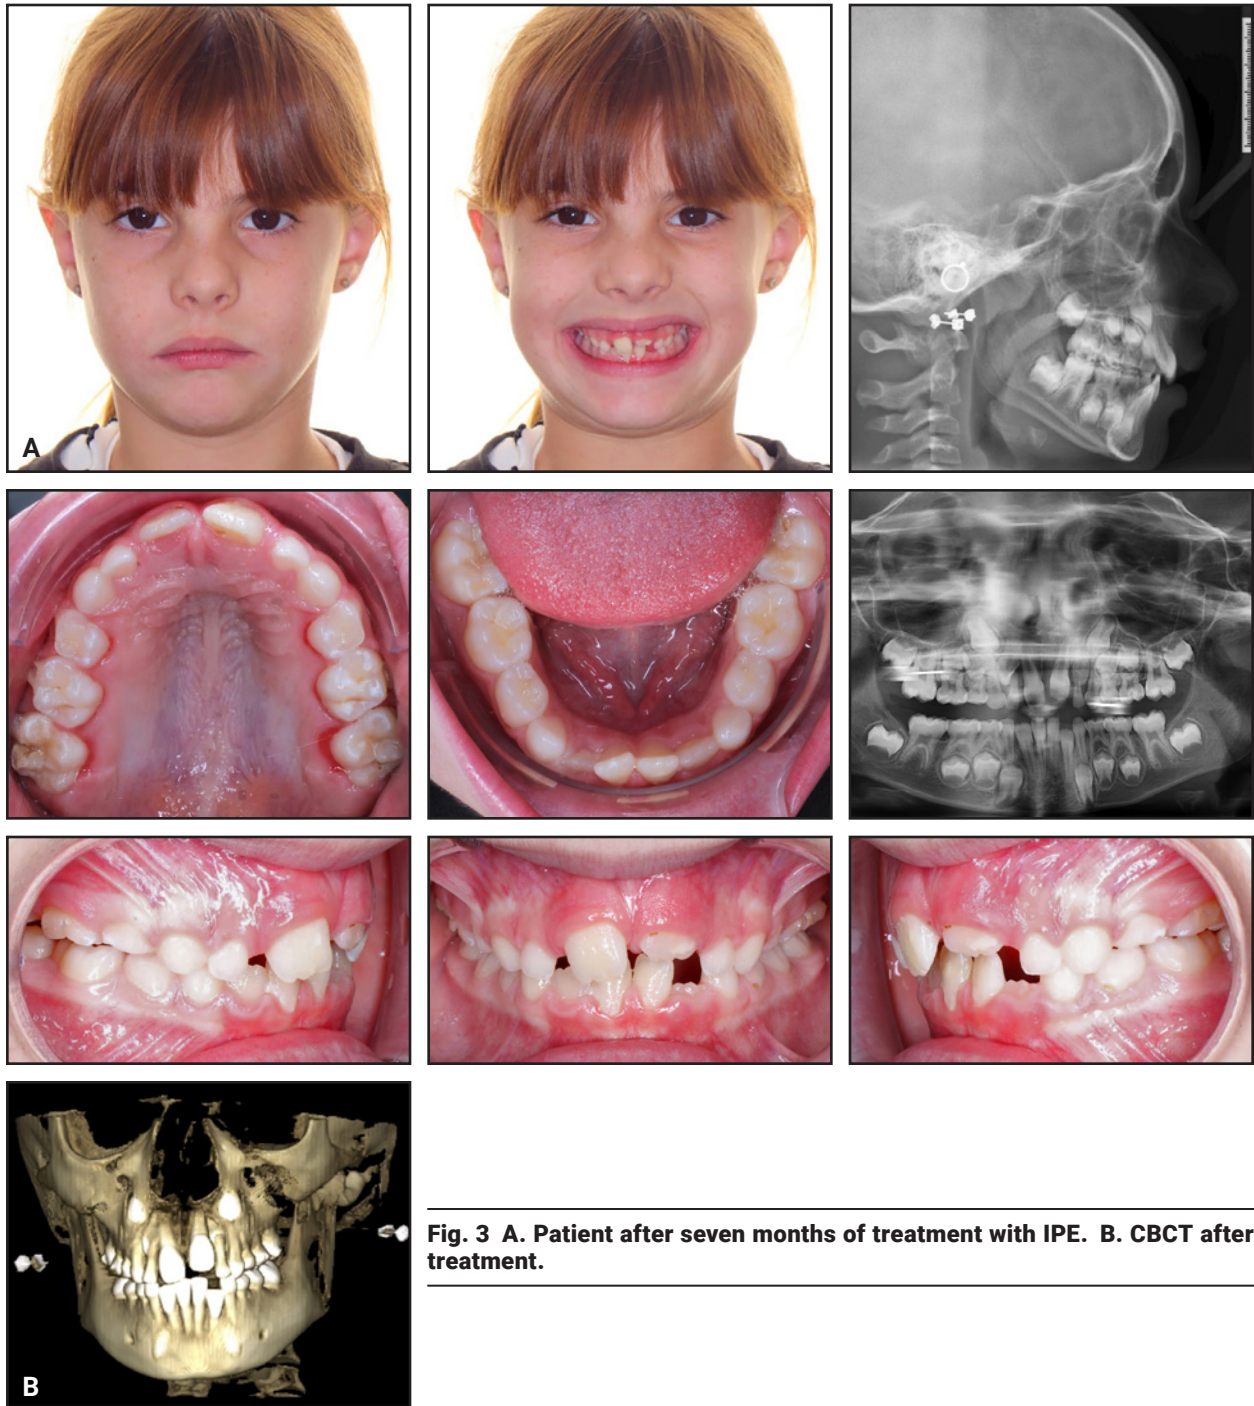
A. Patient after seven months of treatment with IPE. B. CBCT after treatment.
